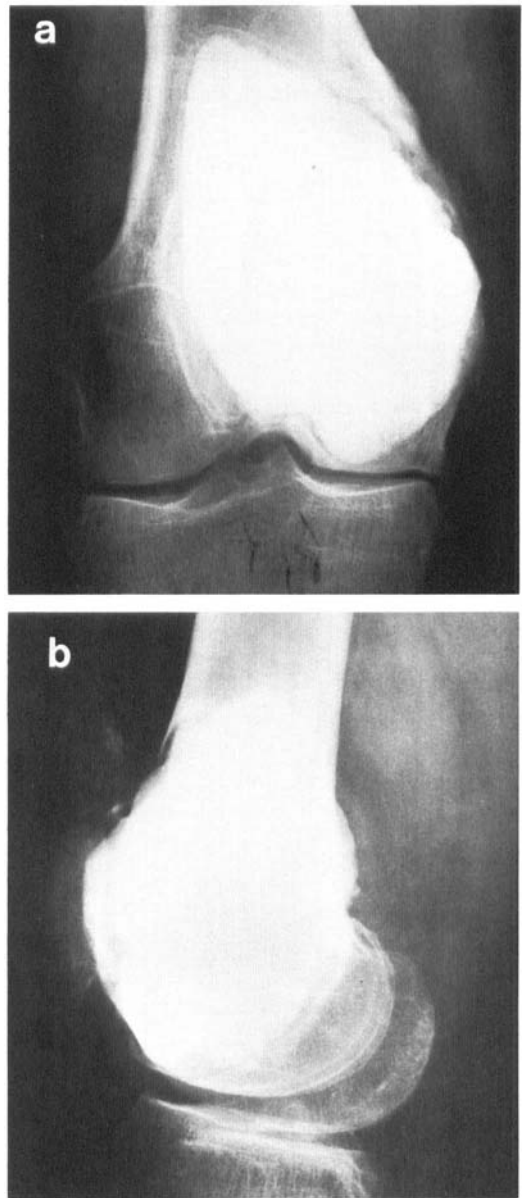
a and b. Postoperative radiographs 9 years after curettage and cementation showing well-demarcated radiolucent zone and Grade I osteoarthritis medially.
